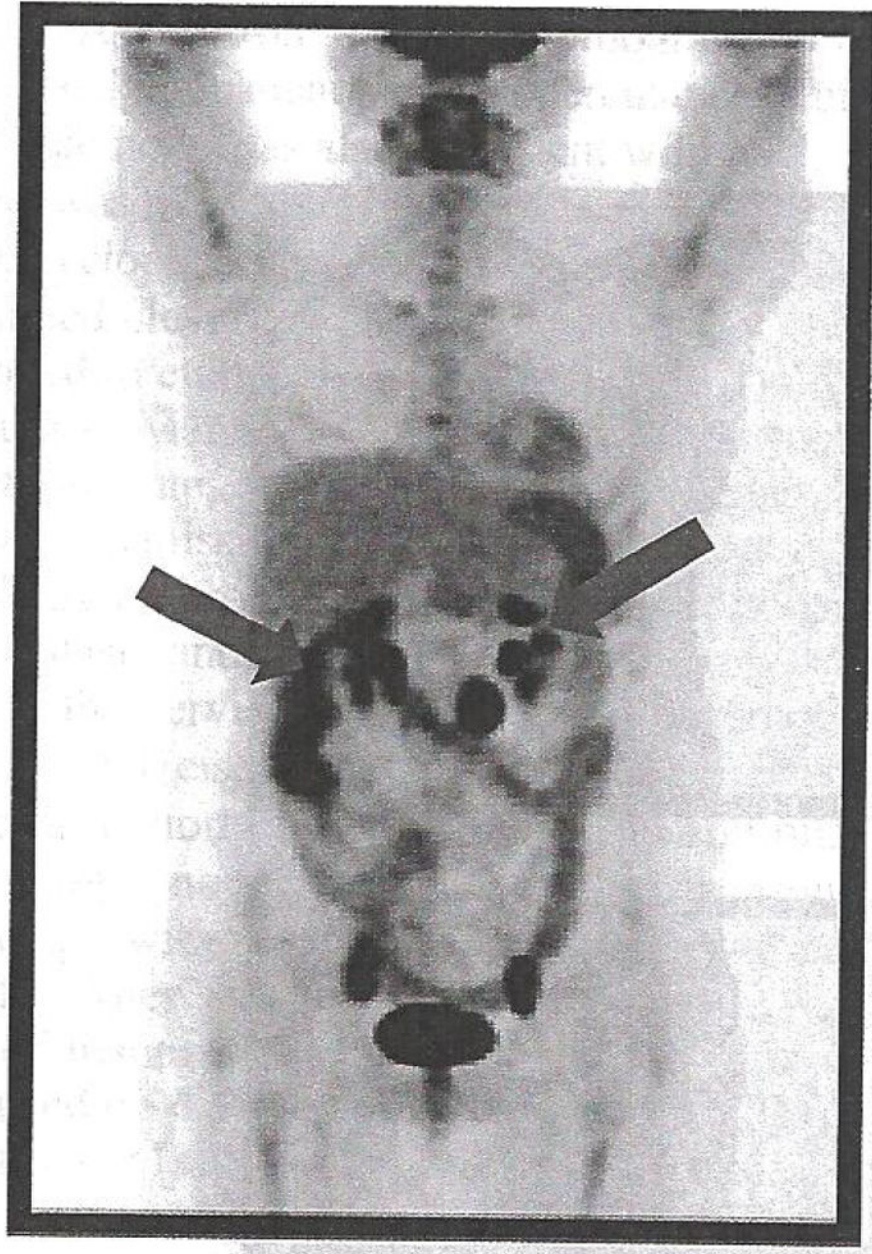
Positron emission tomographic/CT scan revealing widely metastatic disease (red arrows). Note physiologic isotope uptake in brain, renal collecting systems, and bladder.
